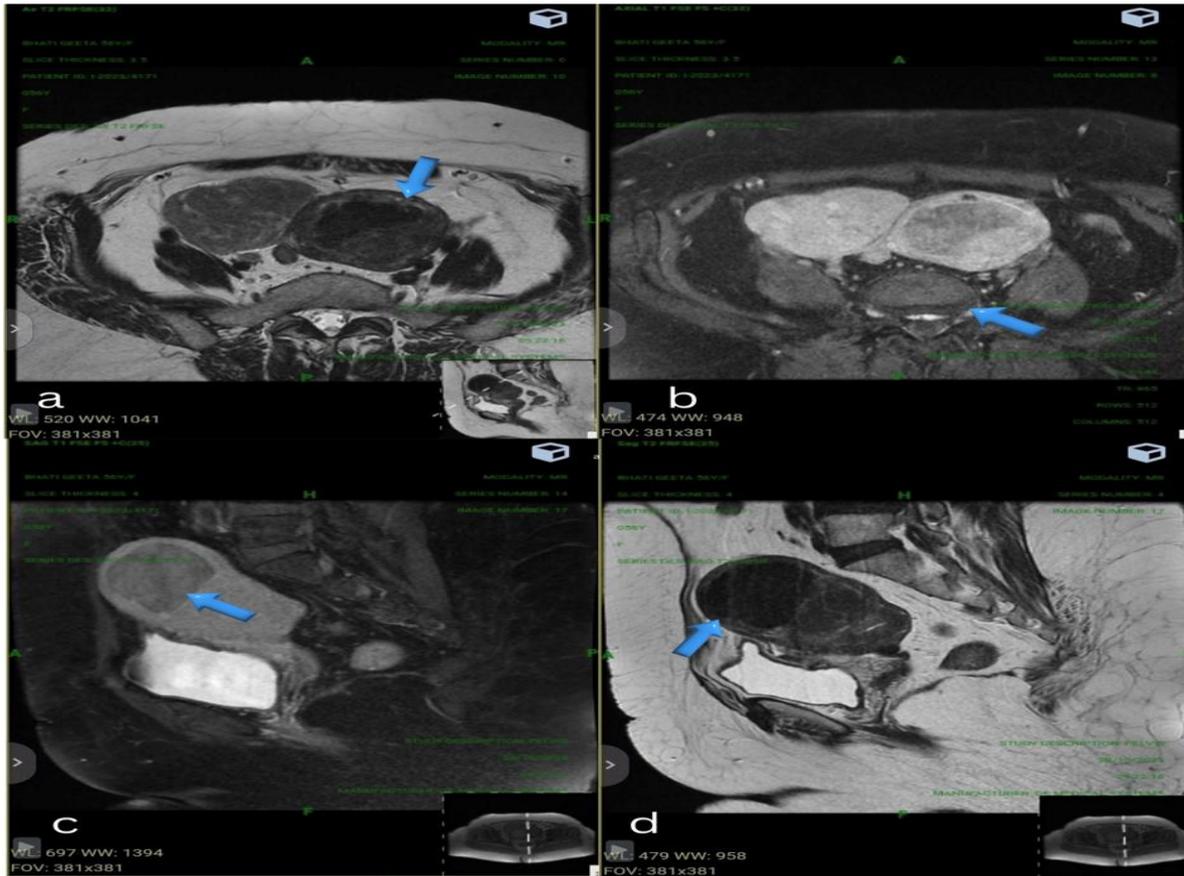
(A-D): Magnetic resonance imaging of uterine leiomyosarcoma of a post-menopausal woman (arrow).
